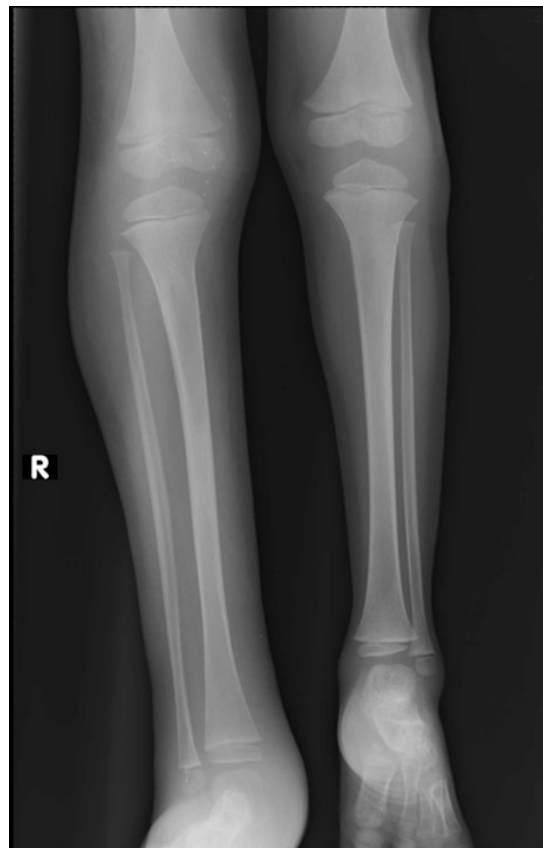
Anteroposterior radiograph of both tibia and fibula shows longer right tibia and fibula bones with fullness of soft tissue in the right leg.
